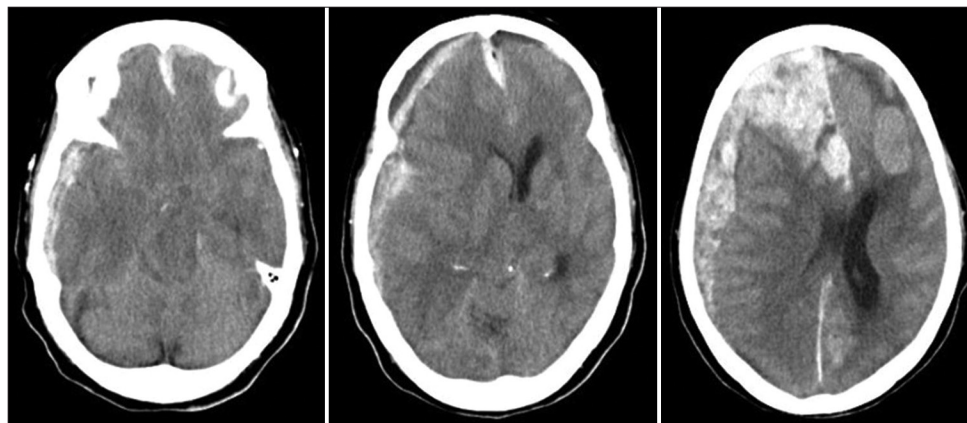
(a-c) Initial head computed tomography reveals right convexity and interhemispheric acute subdural hematoma, (c) mass lesions in the left frontal lobes, and brain herniation.
